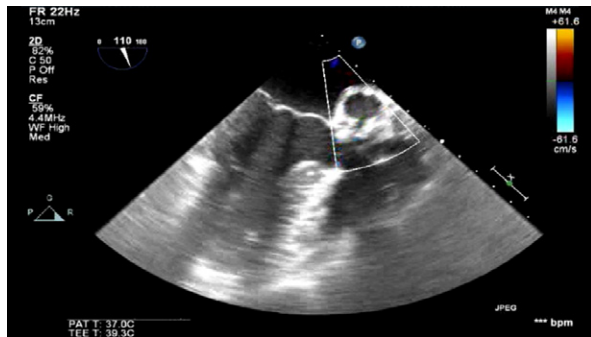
Intraprocedural transesophageal echocardiogram (color-flow Doppler mode) shows blood flow inside the lesion and expansion of the left ventricular outflow tract pseudoaneurysm during systole.
